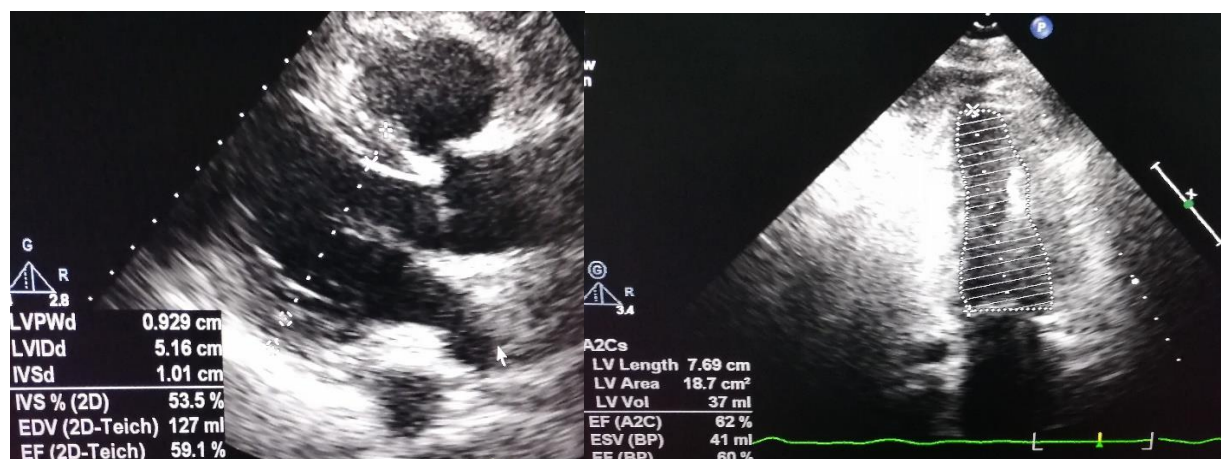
TTE study in subject (10) after DAAs. Left: parasternal long axis view to measure LV end diastolic diameter. Right: Apical 2 chamber view to calculate LVEF by biplane disc summation.
